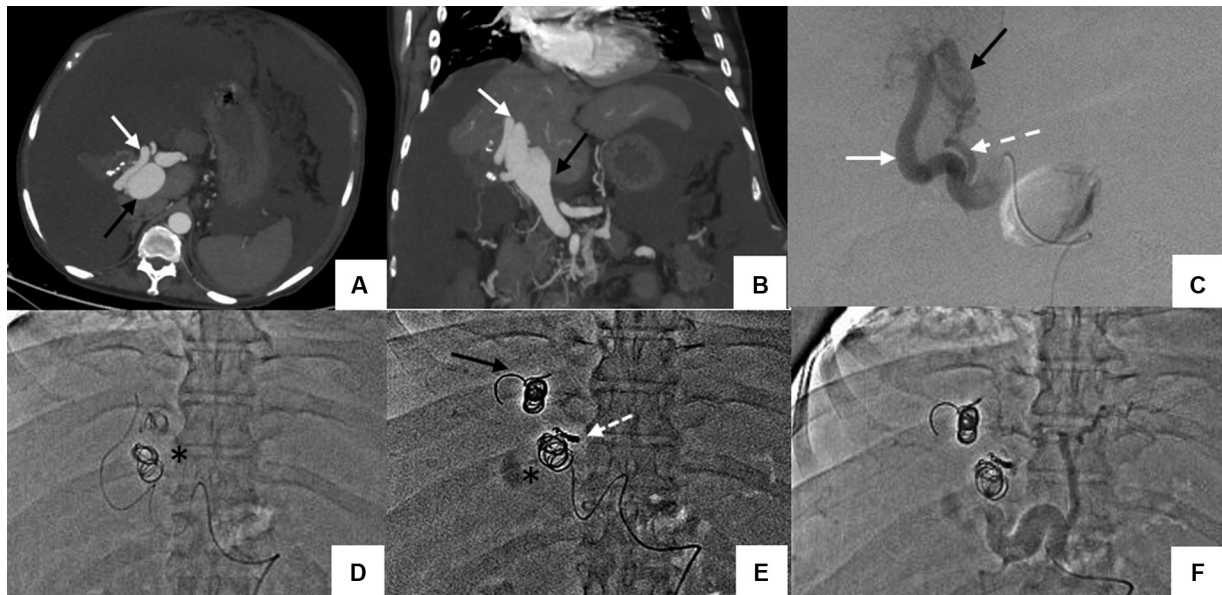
Arteriportal fistula (APF) in a 56-year-old patient who presented with hemobilia. Computed tomography arterial phase images, (A, axial); (B, coronal), demonstrate an APF between the posterior segmental branch of the right hepatic artery (white arrow) and right branch of the portal vein (black arrow). Selective celiac artery angiogram (C) shows early peripheral opacification of portal vein branch (black arrow). A selective arterial angiogram (D) reveals an APF between the right hepatic artery branch (white arrow) and dilated branch of the right portal vein (black). Selective coil embolization of the arterial branch (E). Check angiogram (F) shows no opacification of the hepatic artery branch and APF.
